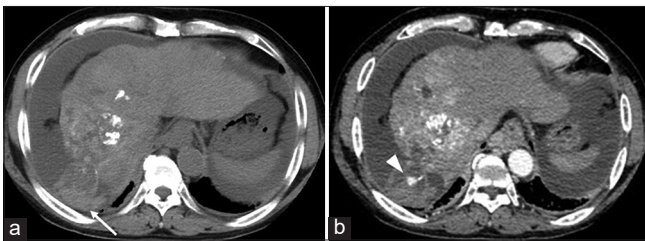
Dynamic contrast-enhanced computed tomography (DCE-CT) performed the next day of the drug-eluting beads transarterial chemoembolization procedure. (a) Pre-contrast images showed a high-density area on the dorsal part of the previously identified segment 8 protruding hepatocellular carcinoma, presumed to be a hematoma (white arrow). (b) A speckled enhancement that seemed to be vascular lake phenomenon was observed within the hematoma in the arterial phase of DCE-CT (white arrowhead).
